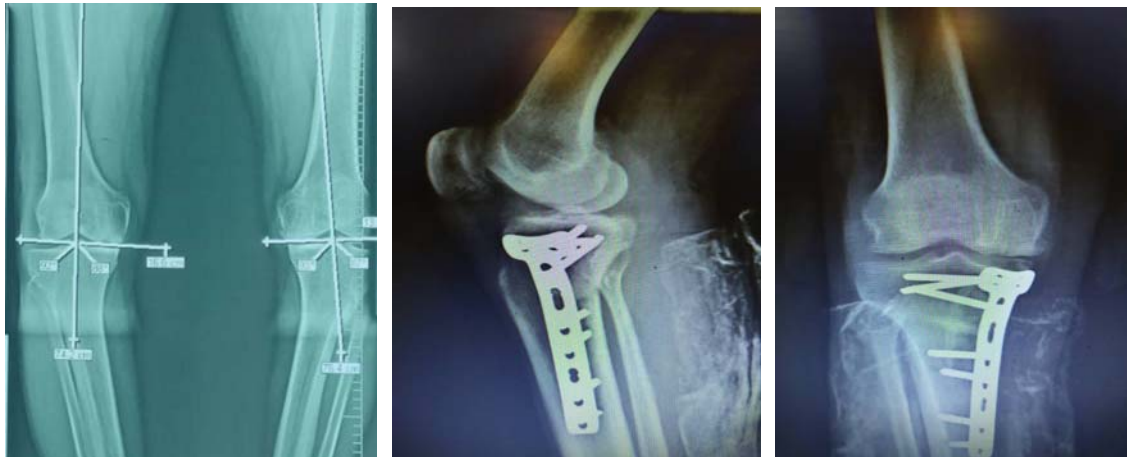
Preoperative evaluation graph, X-ray of the knee in one month after surgery
